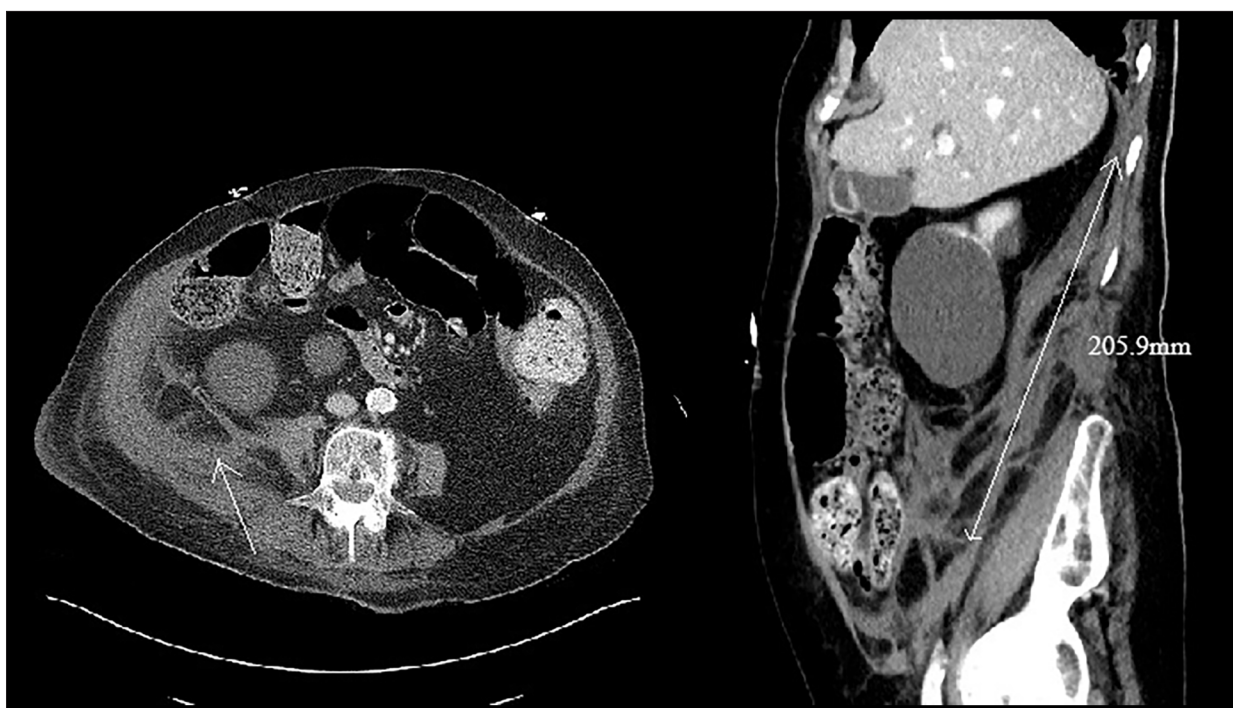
Abdominal and pelvic CT with contrast demonstrating right retroperitoneal hematoma extending from the posterior tip of the liver to the right lower pelvis. The hematoma measured 20.5 cm in the craniocaudal dimension, as is demonstrated on the sagittal plane in the right-side image. The pointer line on the left-side image demonstrates the same, in axial view.
